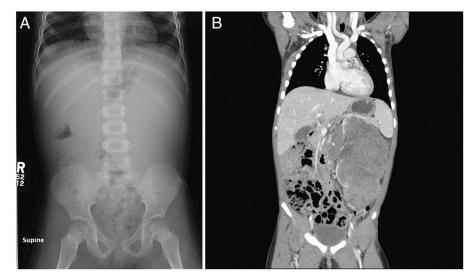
Abdominal radiograph (A) and computed tomographic scan (B) of the abdomen in a patient with Wilms tumor. The patient presented with intermittent gross hematuria and left flank "fullness." Notice the absence of bowel gas in the left flank due to bowel displacement by the tumor.
